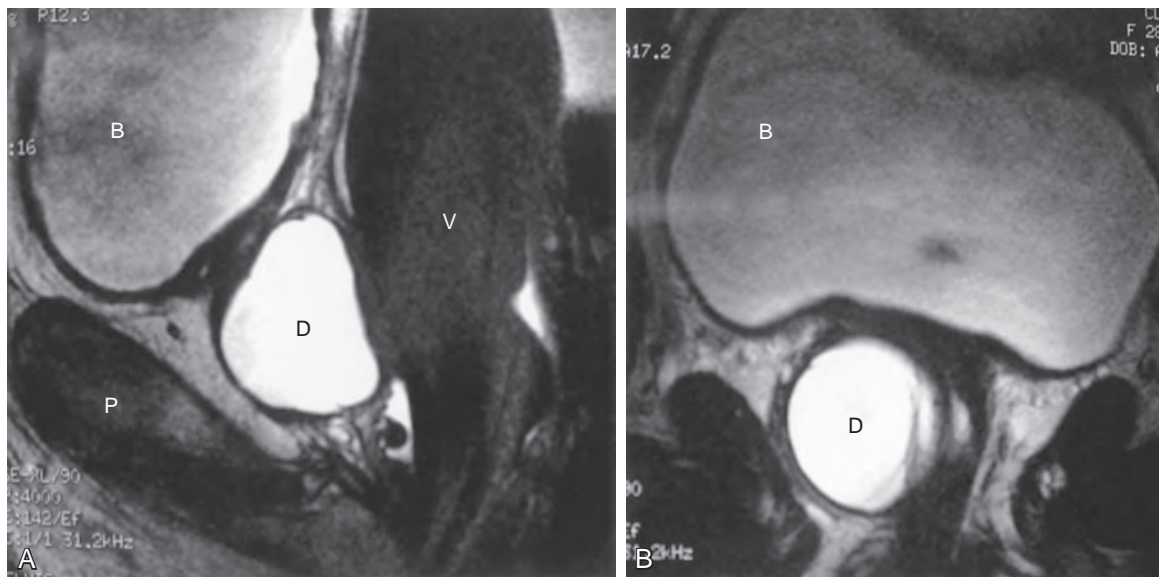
T2 MRI demonstrating a large urethral diverticulum (D) extending to the trigone of the bladder (B) in the sagittal (A) and coronal (B) planes. P, symphysis pubis; V, vagina.
